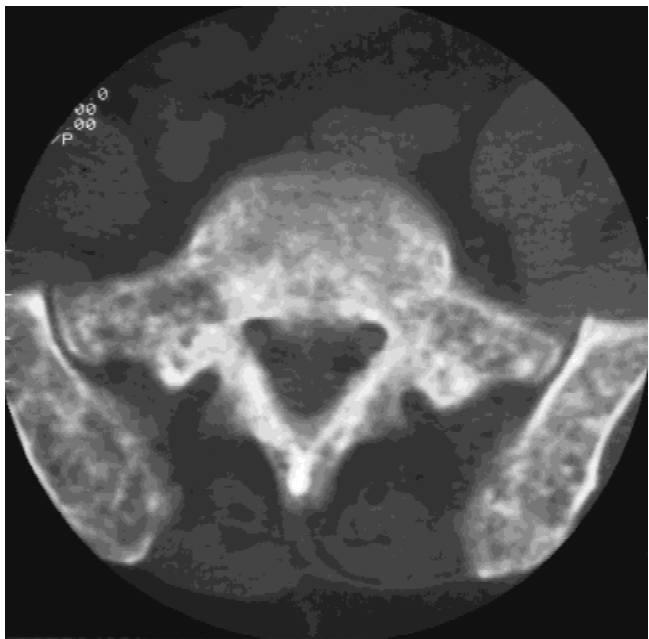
Patient 2. Mixed lytic and sclerotic lesions seen on computed tomographic scan of vertebral body L-5.
